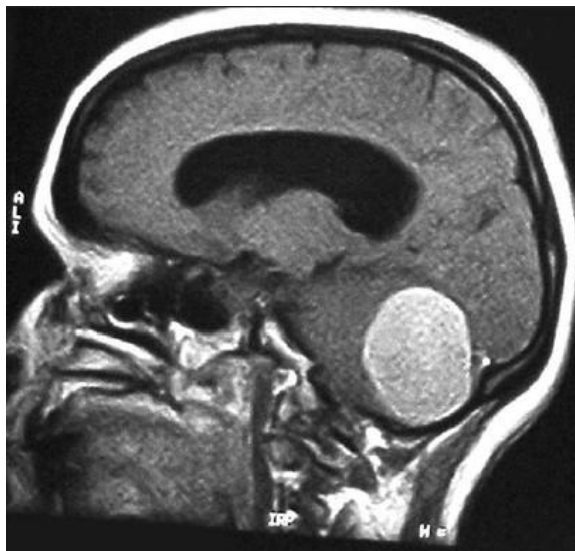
a MRI image showing a posterior fossa tumour.
